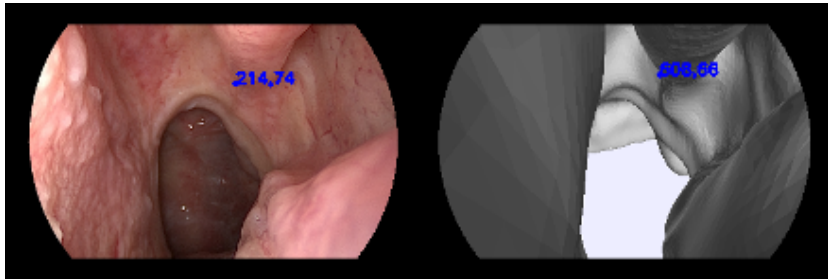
Example of manually selected keypoints from an input image to sample points from the reconstructed mesh (left) and corresponding selected point in CT rendering (right) used for registration.
